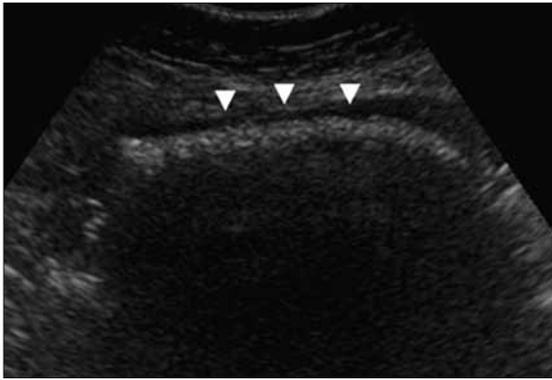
Sonographic examination reveals an echogenic area with a hyperechoic, arc-like surface (*arrowheads*) and clear posterior acoustic shadowing, located in close proximity to the area of collection.
